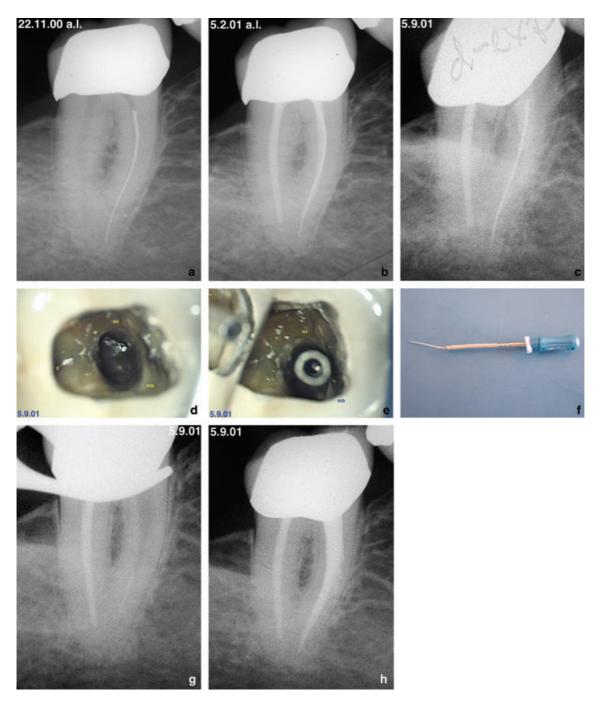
(a) Size 20 reamer fractured by preceding operator. (b) Root canal obturation performed by first dentist without trying to remove the fractured instrument. (c) Radiograph taken after a first attempt to remove the fractured instrument by the referring dentist: most of the old obturation material was removed but the fractured instrument was still tightly sealed into the root canal. (d) Clinical view on the fractured instrument before removal: instrument is located in the mesiolingual canal. (e) Clinical view after pushing a steel tube over the fractured instrument and before introducing a H-File into the tube. (f) Fractured instrument, tube and H-File after successful removal from the tooth. Removal time: 30 min. (g) Radiograph showing empty root canal. (h) Final radiograph after root canal obturation.
